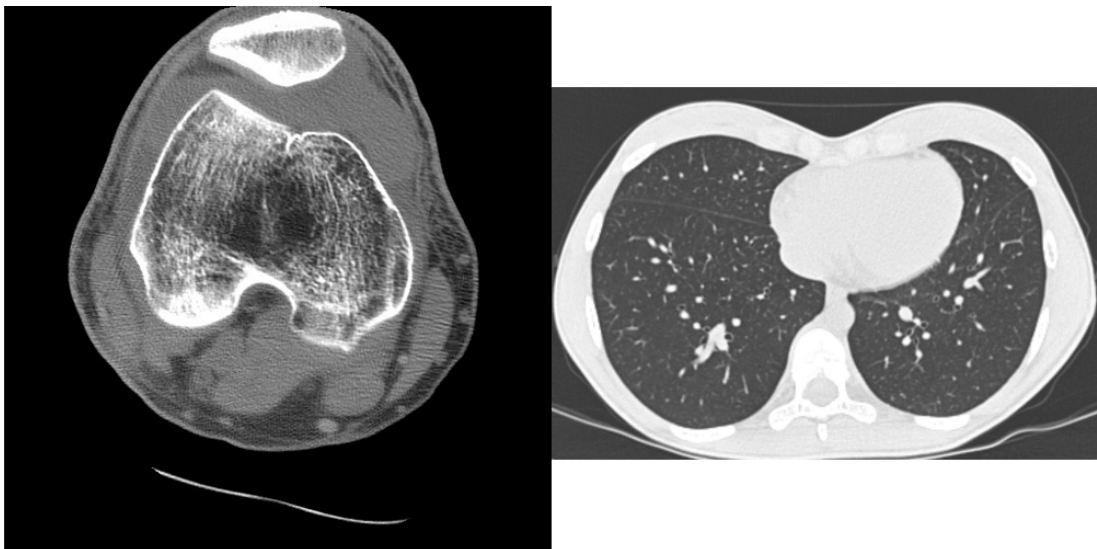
Examples of CT images: knee (left) and lung (right)
